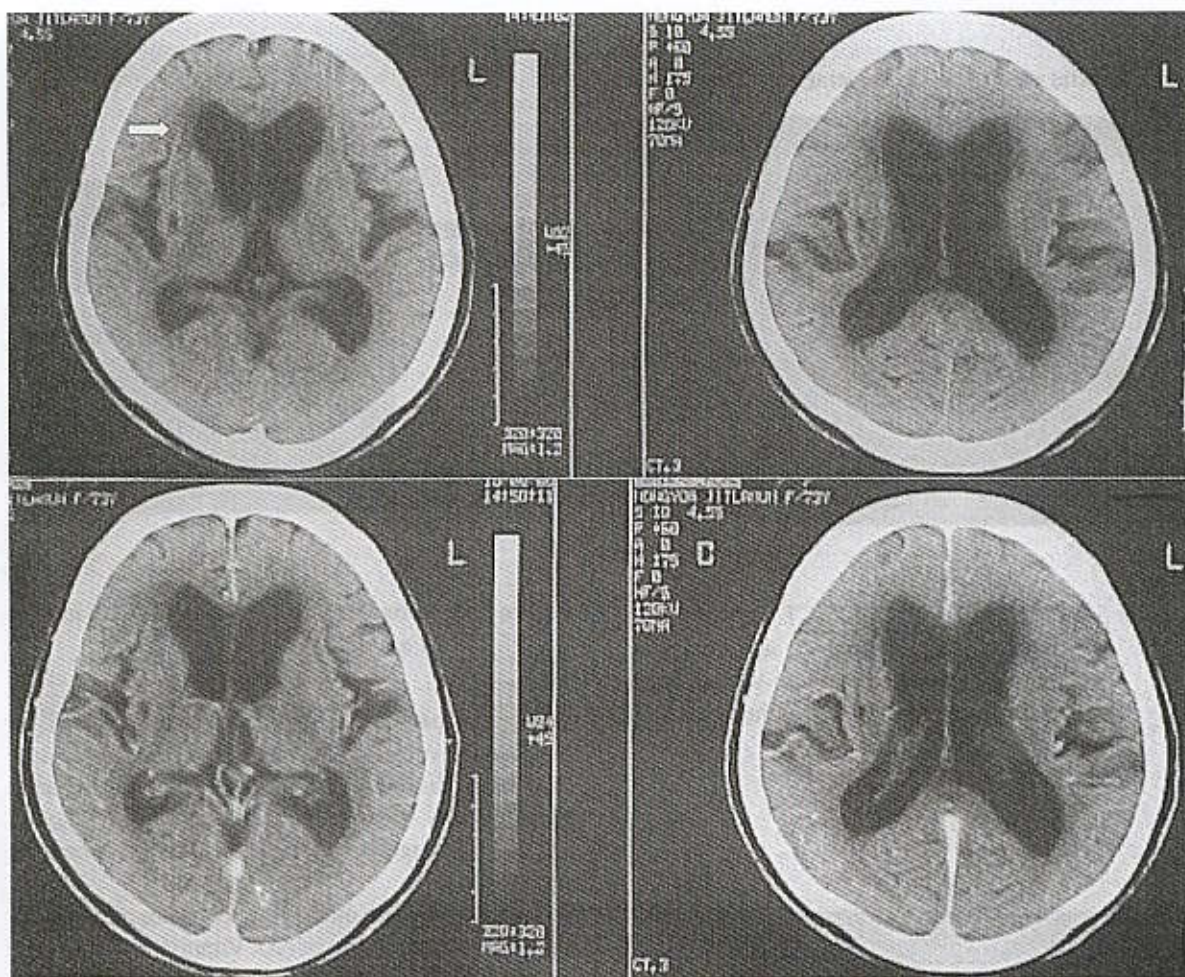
Axial CT pre- (upper row) and post- contrast (lower row) in a patient who had clinical dementia with urinary incontinence and an ataxic gait. There is a combination of disproportionate dilatation of the lateral ventricle (tense-round appearance of the frontal horn) to the depth of the cerebral sulci and periventricular white matter (arrow).
